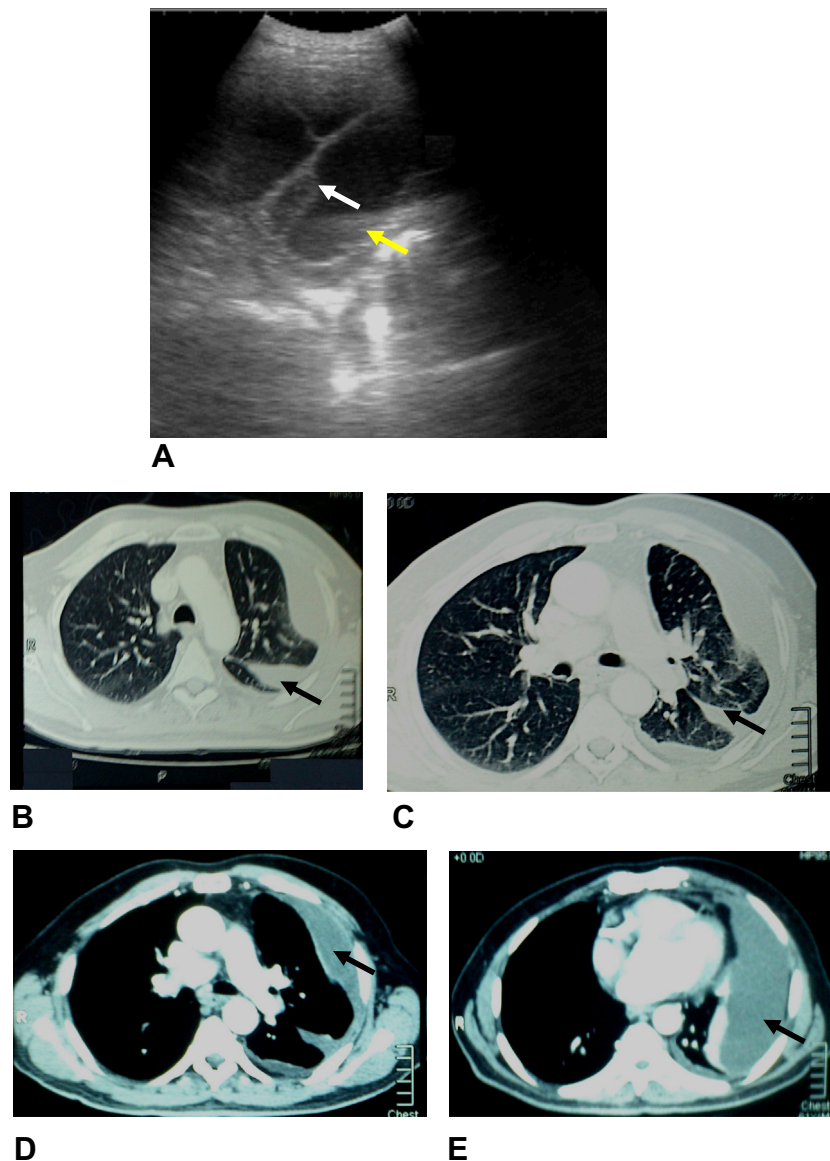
(A) Chest US in B-mode shows a moderate amount of encysted pleural effusion which is associated with marked pleural thickening. The dependent part of the effusion shows increased echogenicity (yellow arrow) with thick septations (white arrow) inside. These ultrasonographic findings are keeping with complex septated type of effusion. (B–E) The corresponding chest CT axial images in lung (B and C) and mediastinal (D and E) window settings display moderate amount of left-sided encysted pleural effusion (arrowed) with partial compression collapse of the underlying lung parenchyma. Biochemistry confirmed the suspected exudative nature of the effusion.
